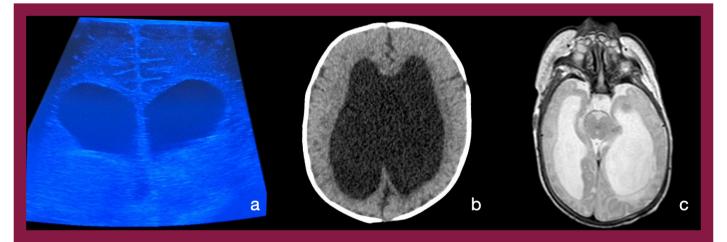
(a) Ultrasonography, (b) computed tomography and (c) magnetic resonance imaging in the diagnosis of hydrocephalus in patients with myelomeningocele
